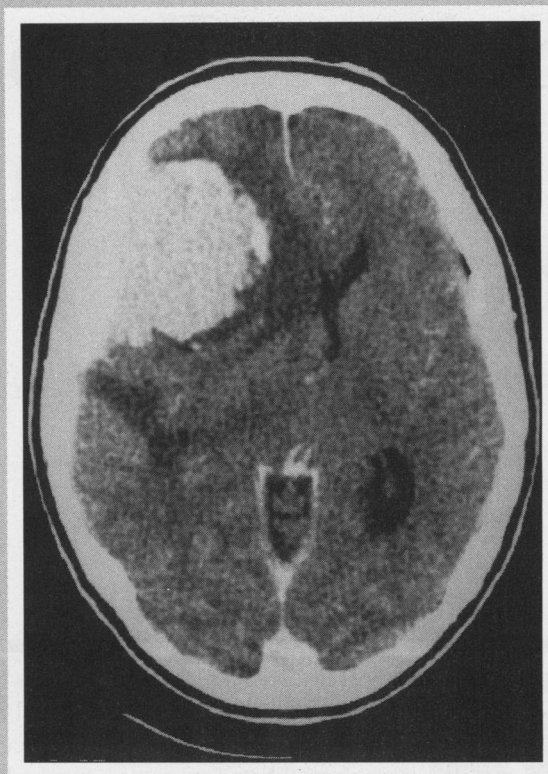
Computed tomography scan from case 2: Low-density lesion in the left occipital lobe has the typical appearance of an infarct and was presumed to be responsible for the right homonymous field loss.
